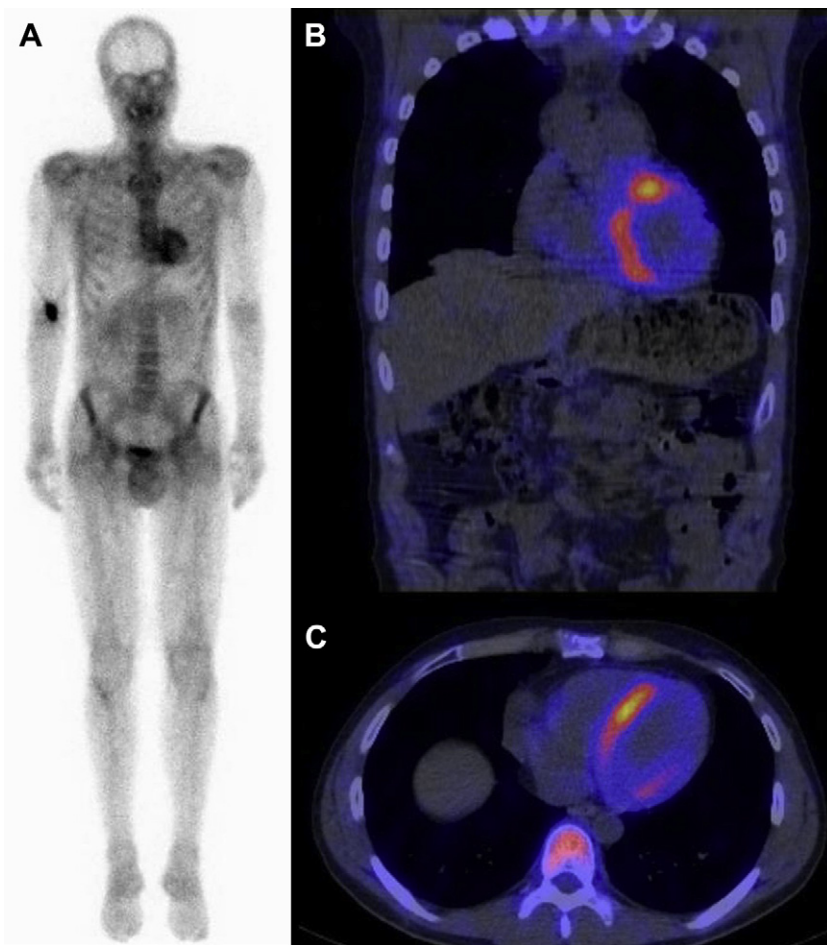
Technetium Tc 99m-methylene diphosphonate bone scintigraphy in a 31-year-old man with ATTR amyloidosis. (A) Total body scan with increased cardiac uptake and soft tissue uptake. The skeletal uptake is relatively diminished. (B) Coronal and (C) transverse single photon emission-computed tomography/CT images of the heart showing increased uptake in the ventricular walls.
